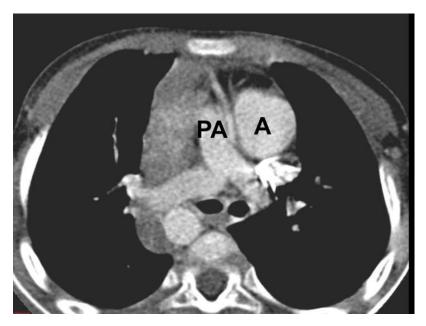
CT axial image of 10 year old boy with double outlet left ventricle has aortic root (A) and main pulmonary trunk (PA) arising in a parallel plane with aorta at left side and main pulmonary trunk at right side, which is designated as {_, _, L-MGA}.
